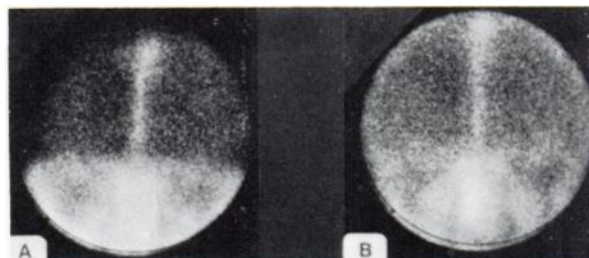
Static scintigrams in same subject with (A) and without (B) application of headband. Both consist of first 300,000 counts recorded after bolus release.
